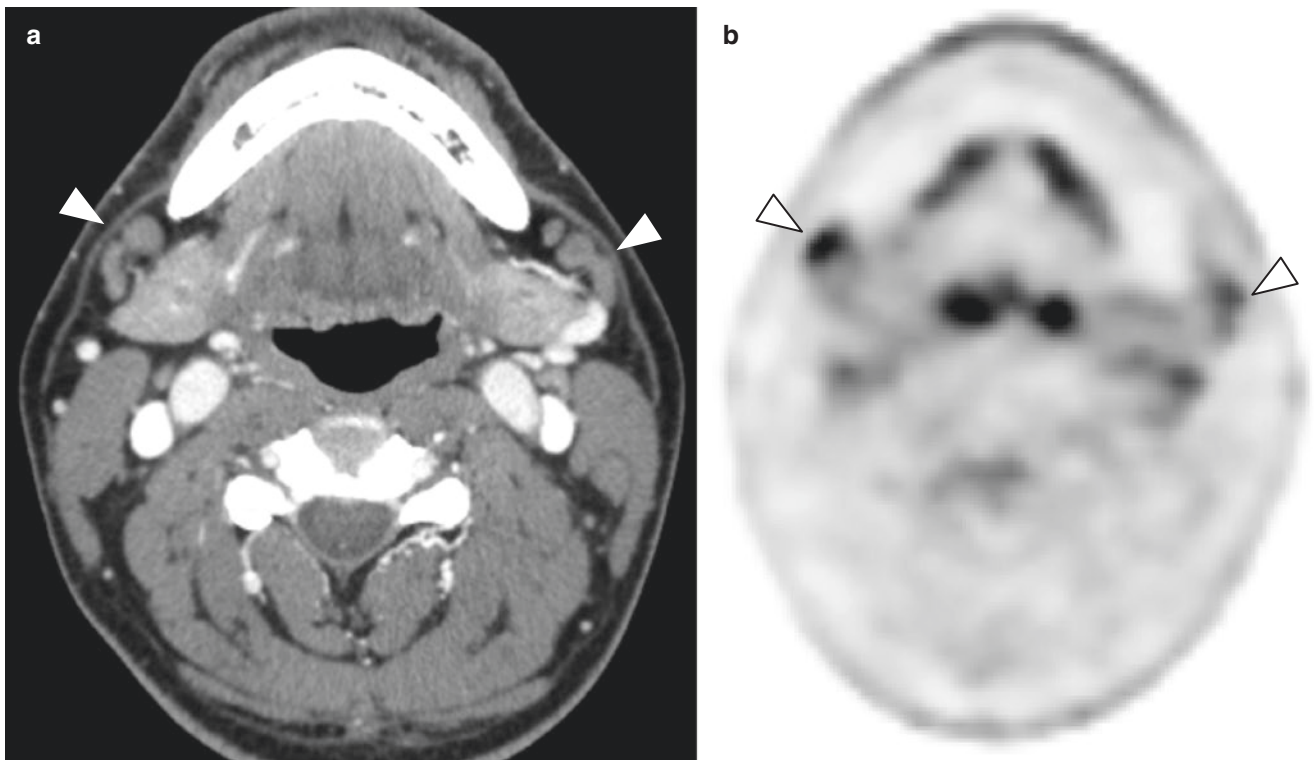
Hyperplastic bilateral level IB nodes (a, b, arrowhead) reveal well-defined margin and lobulated shape on CECT (a). FDG-PET shows false-positive uptake (b)
